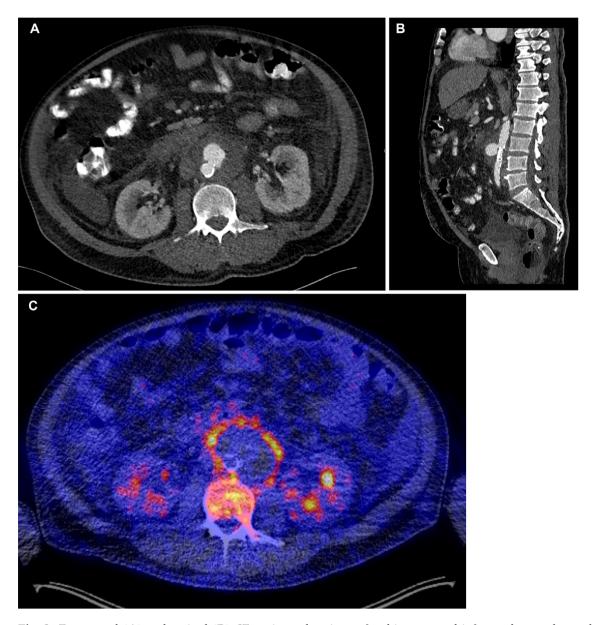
Transversal (A) and sagittal (B) CT-angiography views of a thin stemmed infrarenal ventral saccular mycotic aortic aneurysm, with thickening of the aortic wall, soft tissue stranding, and mural thrombus formation. (C) Transversal ¹⁸F-FDG PET/CT view of the same patient at the level as Figure 1A that shows a heterogeneous uptake of ¹⁸F-FDG in the aortic wall.
